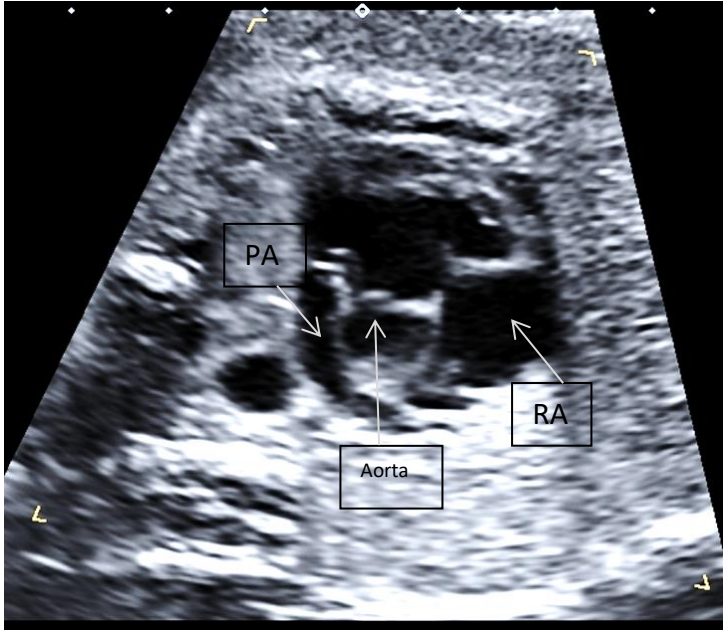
Tetralogy of Fallot from the parasternal short axis view. PA: Pulmonary artery. RA: right atrium.
